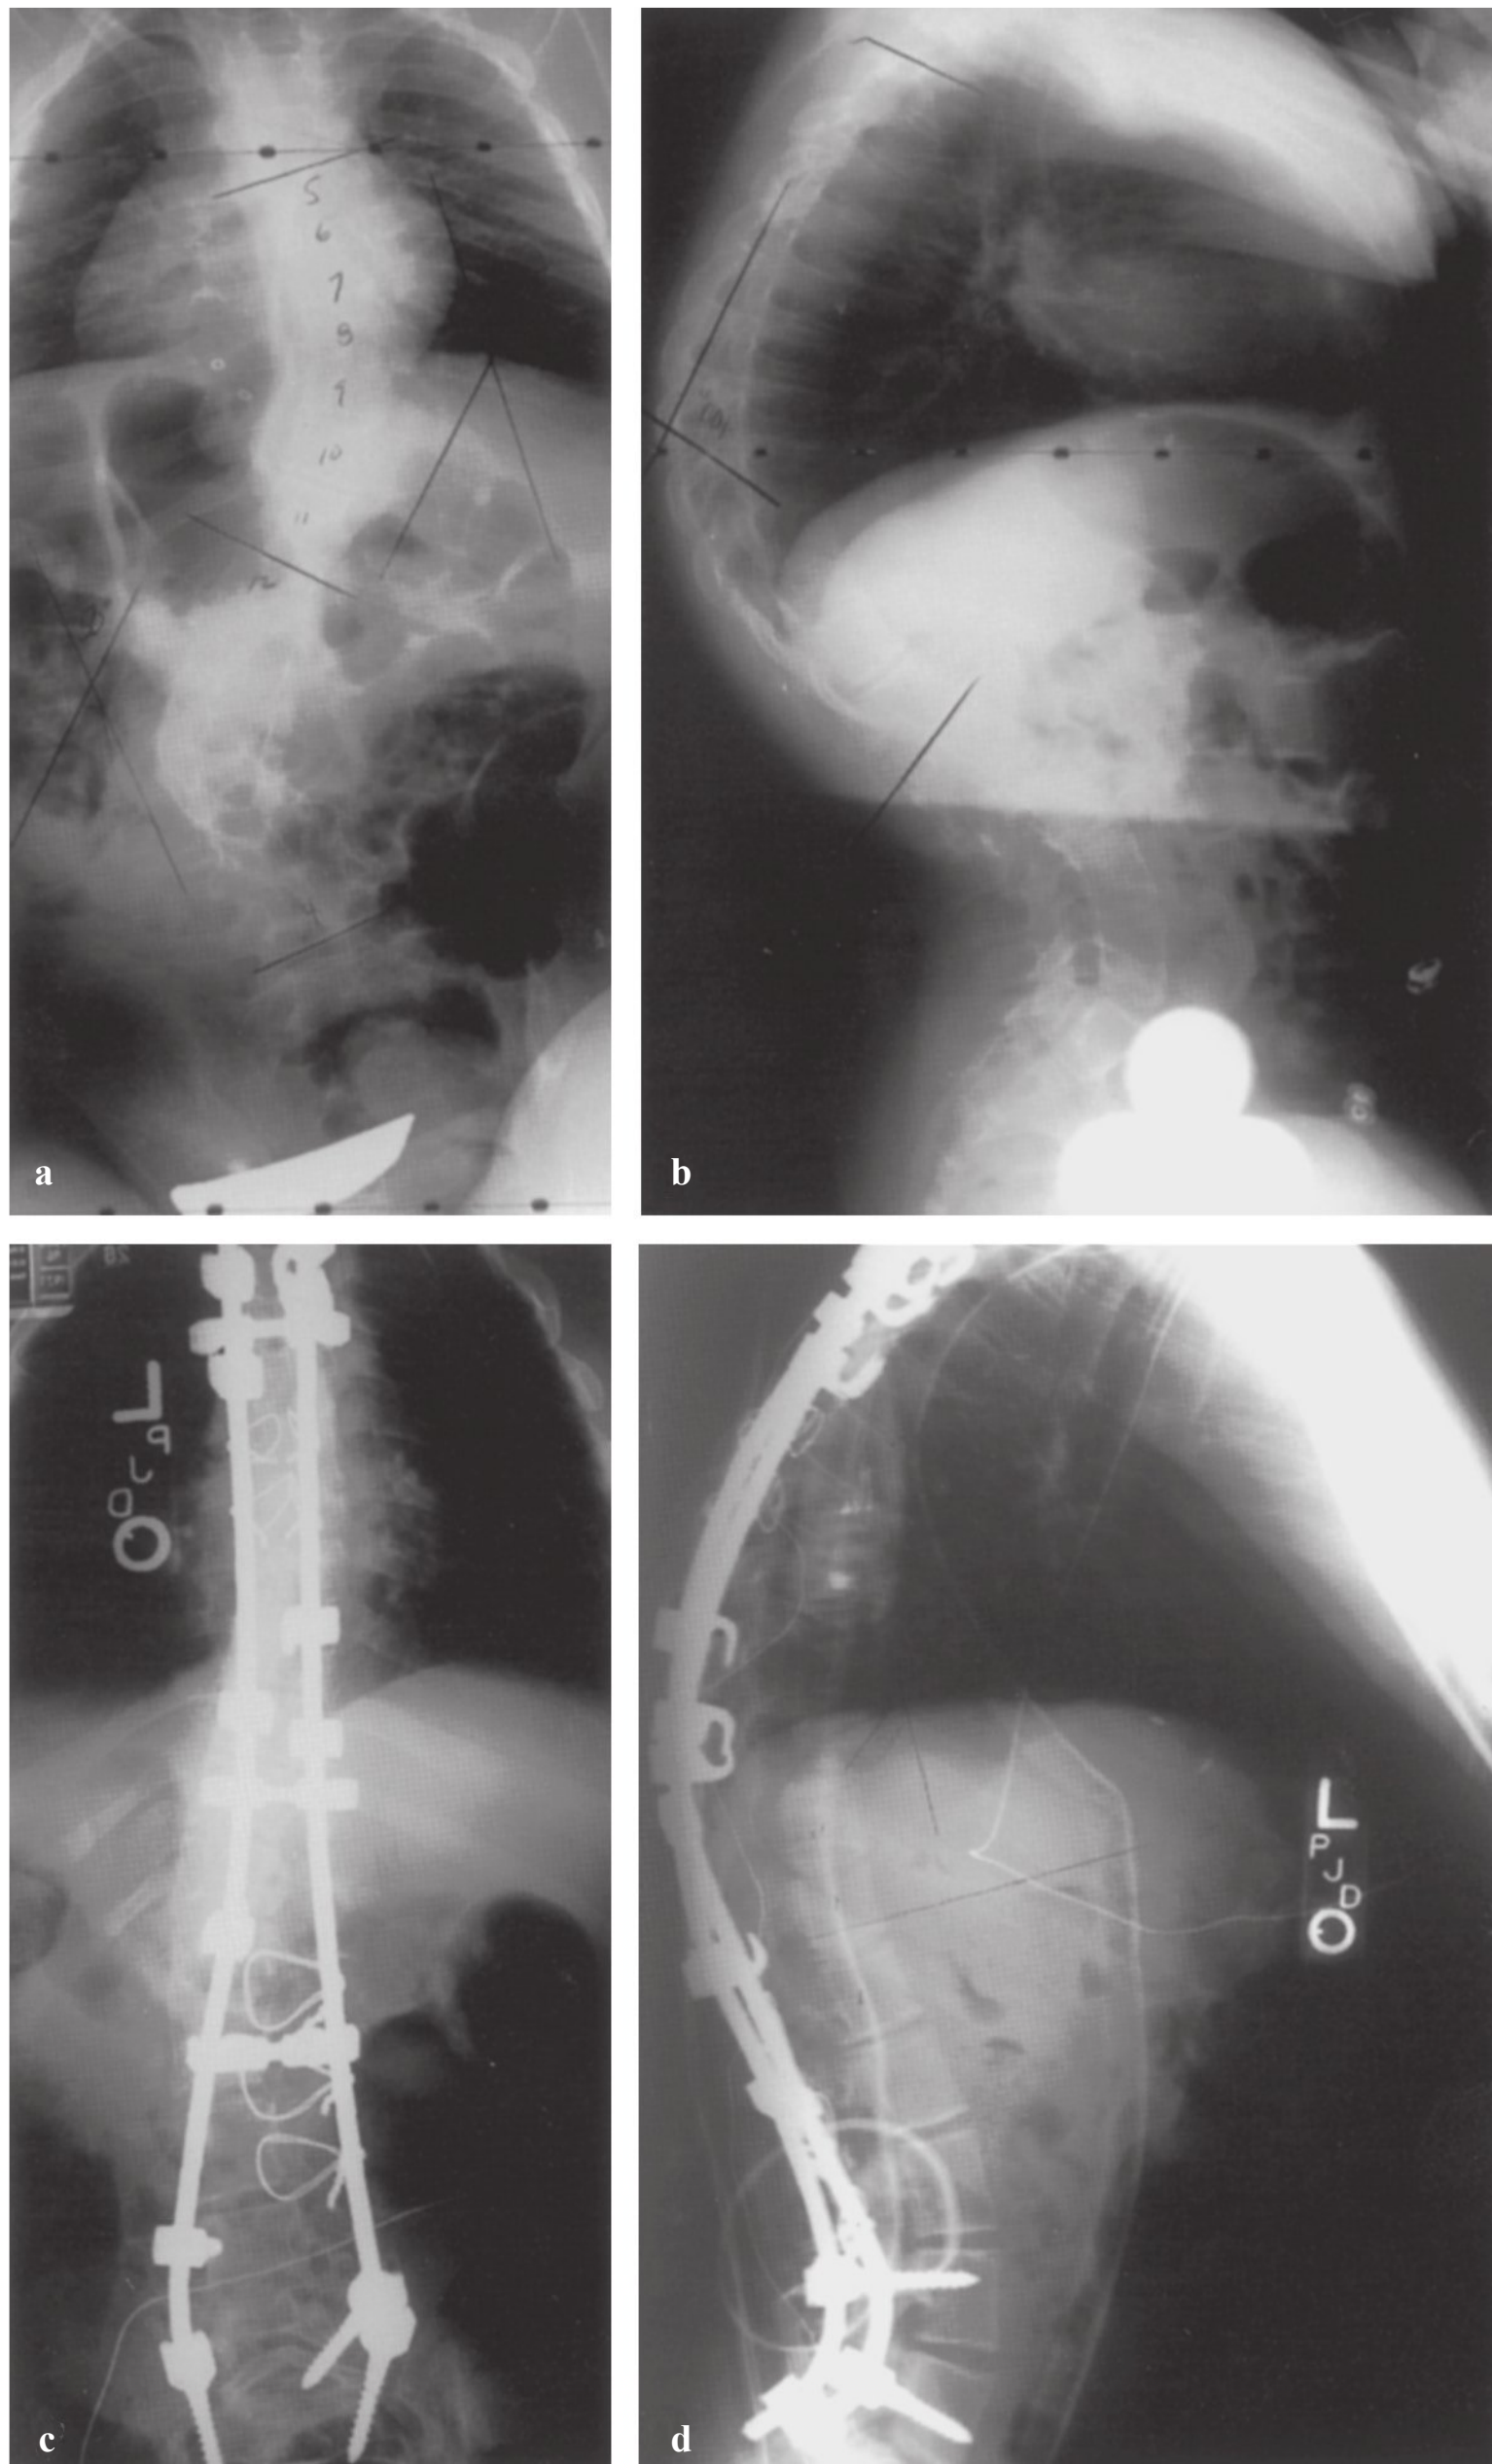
A 13-year-old boy with neuromuscular scoliosis. (a) Anteroposterior and (b) lateral radiographs. There appears to be lumbar hyperlordosis and a compensatory thoracic kyphosis. (c,d) Postoperative radiographs demonstrate a combination of pedicle screw, hook, and sublaminar wiring fixation.
